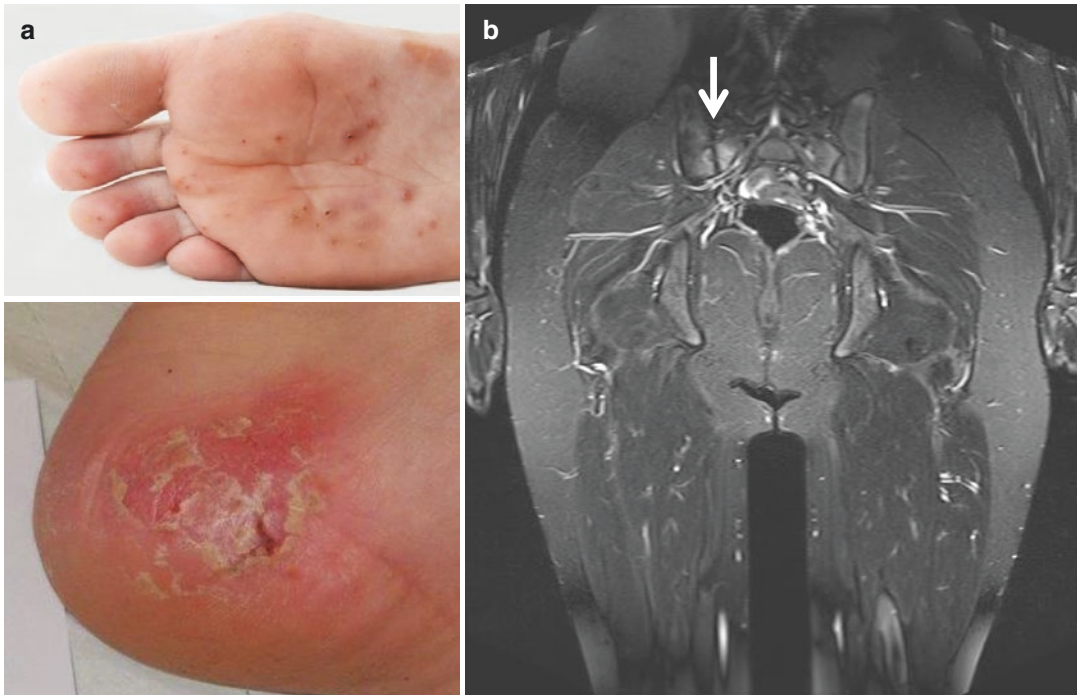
Extrasosseous symptoms in patients with CNO/CRMO. (a) Palmoplantar pustulosis in an 11-year-old patient with severe CRMO (upper panel), and in a 13-year-old female patient with monofocal CNO (lower panel). (b) Whole body MRI scans (coronary TIRM sequences), showing juxta articular signal enhancement in the os
